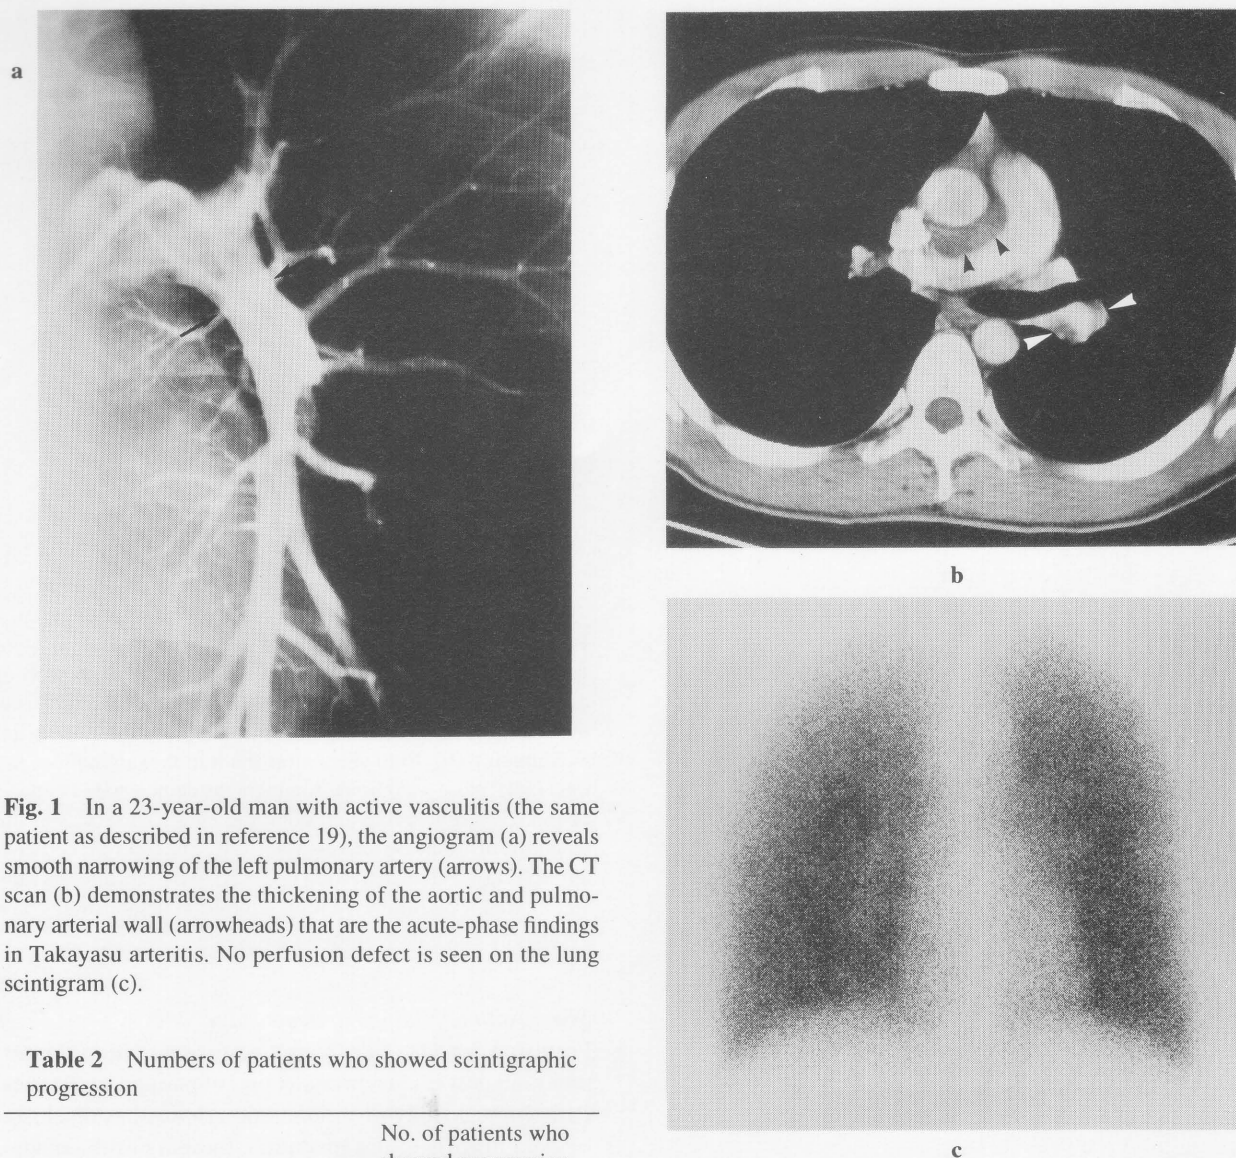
In a 23-year-old man with active vasculitis (the same patient as described in reference 19), the angiogram (a) reveals smooth narrowing of the left pulmonary artery (arrows). The CT scan (b) demonstrates the thickening of the aortic and pulmonary arterial wall (arrowheads) that are the acute-phase findings in Takayasu arteritis. No perfusion defect is seen on the lung scintigram (c).
